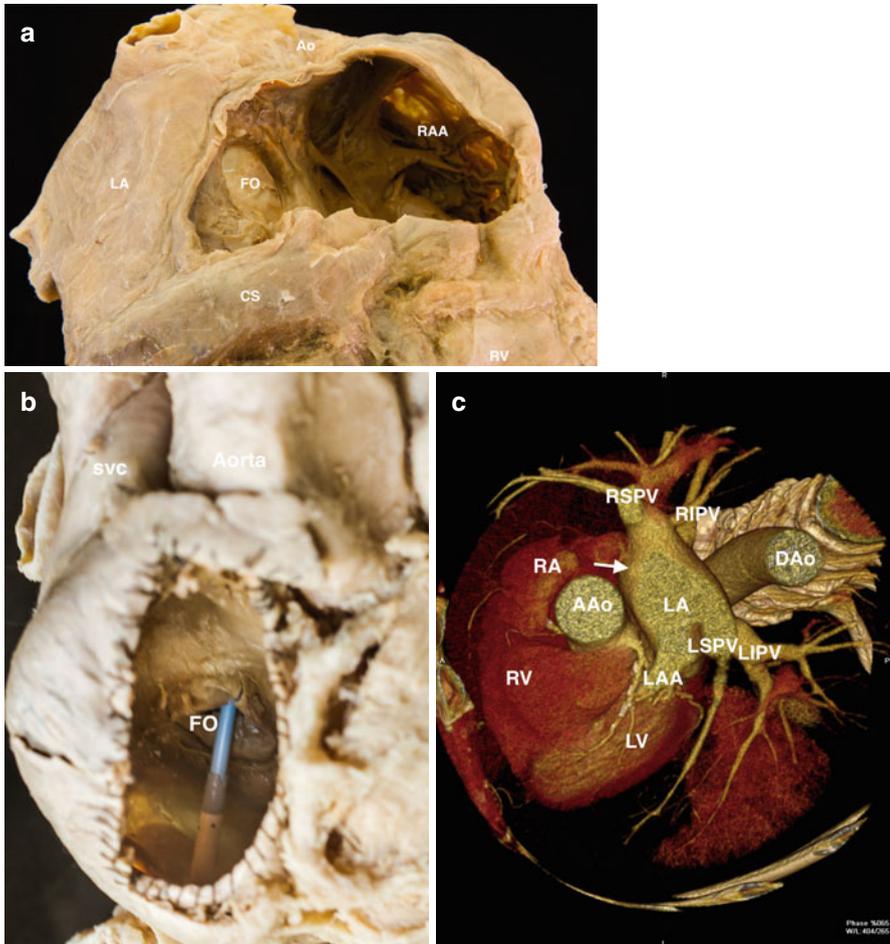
Relevant anatomy in a trans septal approach. In the top image the fossa ovalis (*FO*) is posterior to the aorta (*Ao*). Also seen in this image is the right atrial appendage (*RAA*) anteriorly, the coronary sinus (*CS*) posteriorly and the left atrium (*LA*). The mid image shows a trans-septal sheath engaging the fossa ovalis (*FO*) posterior to the aorta). The image at the bottom is a CT showing the right atrium (*RA*) and left atrium (*LA*). The fossa ovalis (*arrow*) is posterior to the ascending aorta (*AAo*). Also seen in this image is the right superior pulmonary vein (*RSPV*), right inferior pulmonary vein (*RIPV*), left superior pulmonary vein (*LSPV*), left inferior pulmonary vein (*LIPV*), left atrial appendage (*LAA*) as well as the right ventricle (*RV*), left ventricle (*LV*) and descending aorta (*DAo*)
